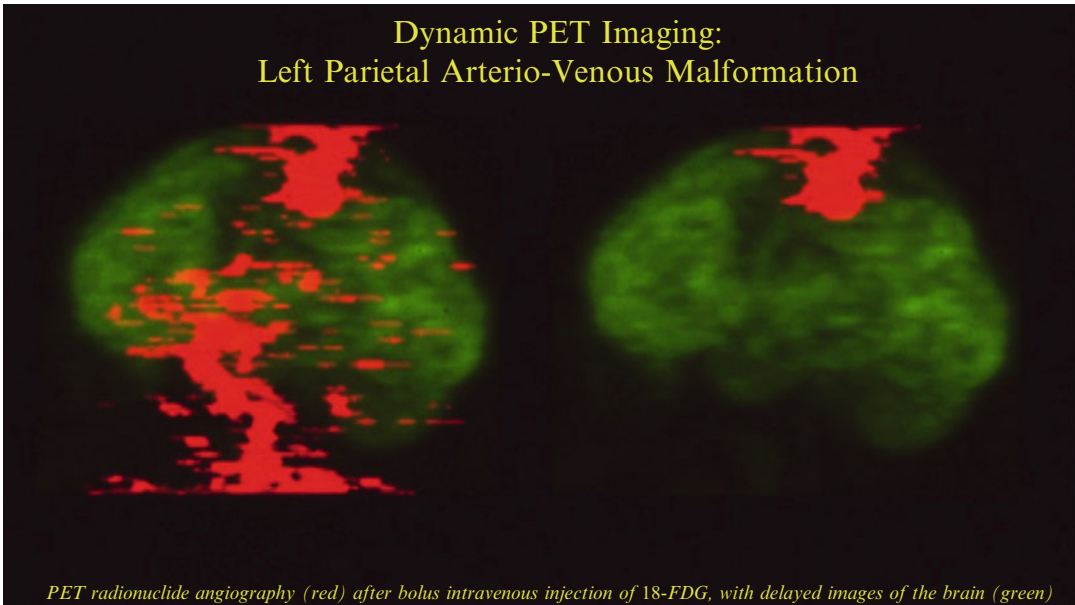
Metabolic depression within AVM area as revealed by dynamic PET imaging with 18F-FDG
